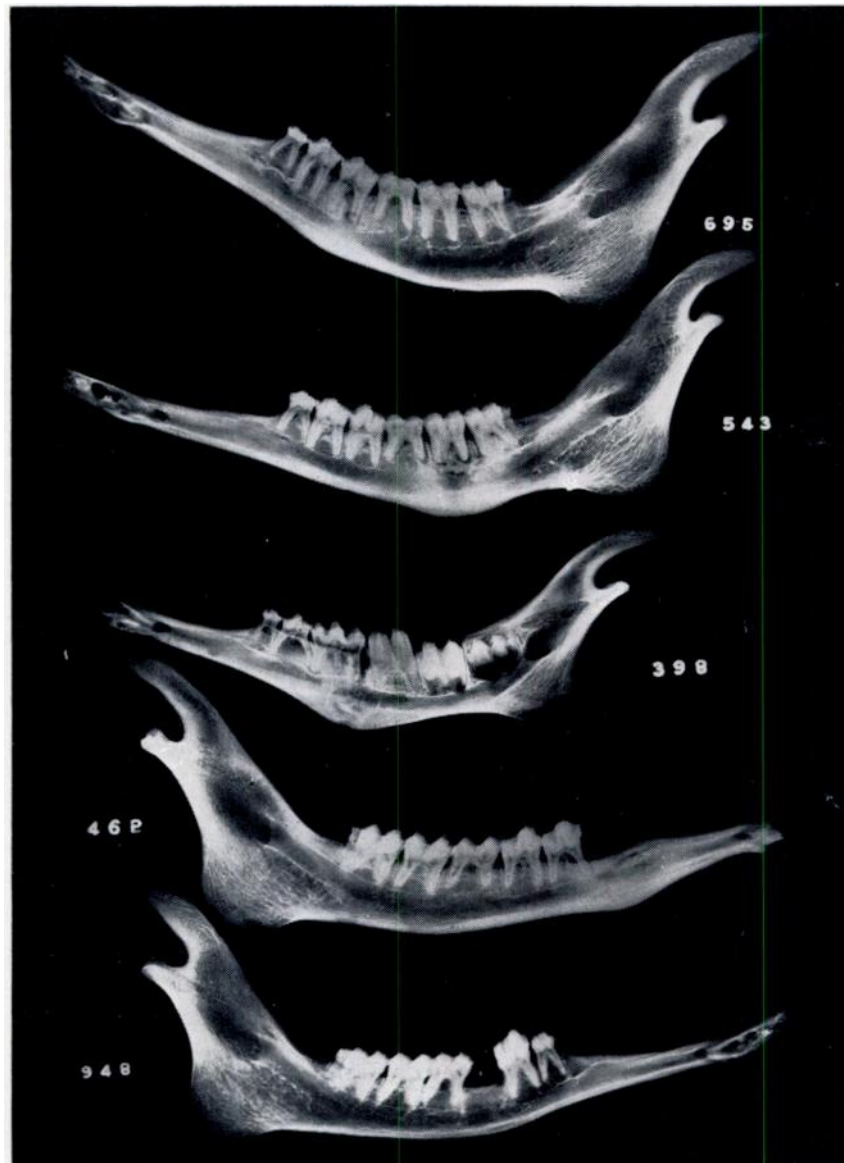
Radiographs of the barren-ground caribou mandibles shown in Fig. 1. (see Results for description of radiographic findings).
